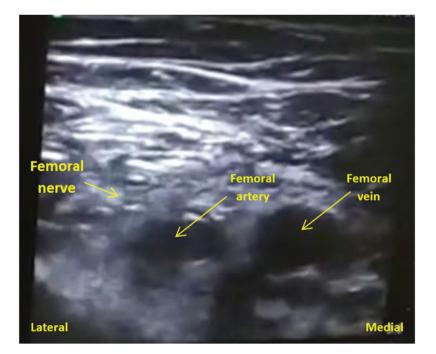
Ultrasound view of the femoral neuro vascular bundle.
